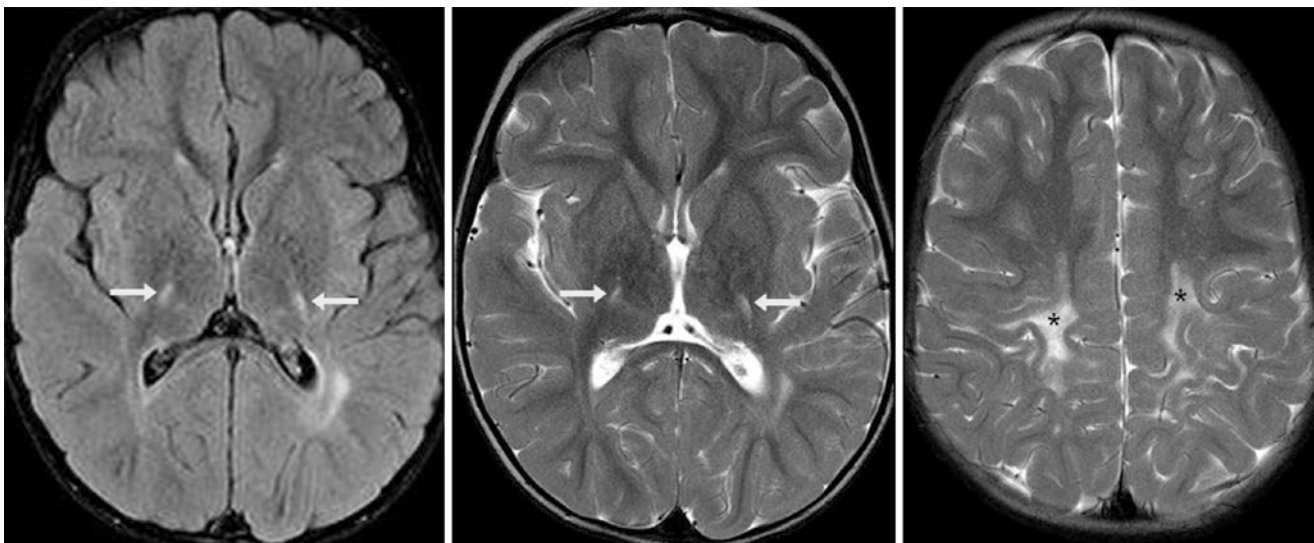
Comparison case of globoid cell leukodystrophy (Krabbe disease). In a 3-year-old with Krabbe disease, a 3 T MRI depicted characteristic bilateral CST abnormalities (*arrows*) within the PLICs on
